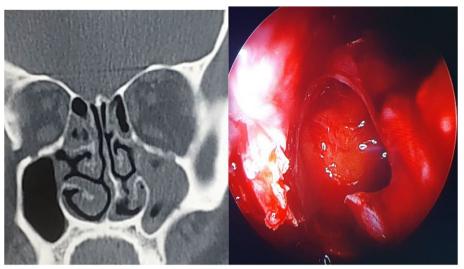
Preoperative CT scan and intraoperative endoscopic picture of left maxillary sinus. Left showing pre-operative CT scan with maxillary sinus opacity, on right side showing intraoperative endoscopic picture of the same patient after 4 weeks. Maxillary sinus is clear and disease-free intraoperatively
